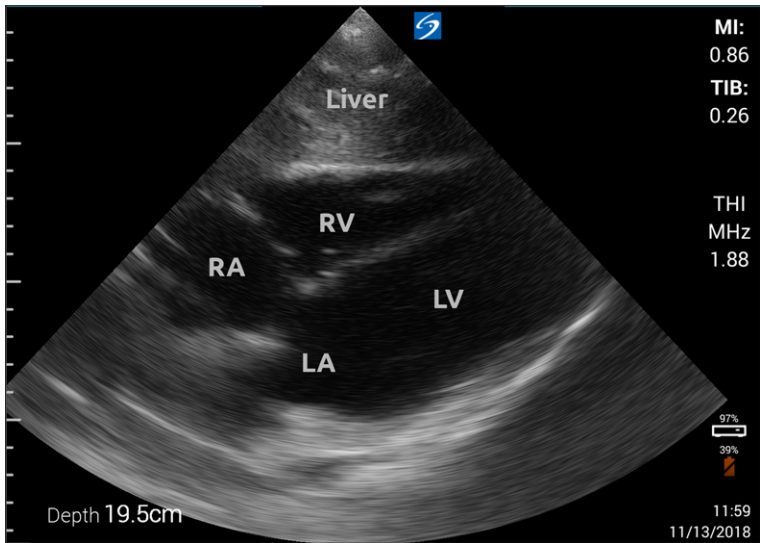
An ultrasound image of the heart
